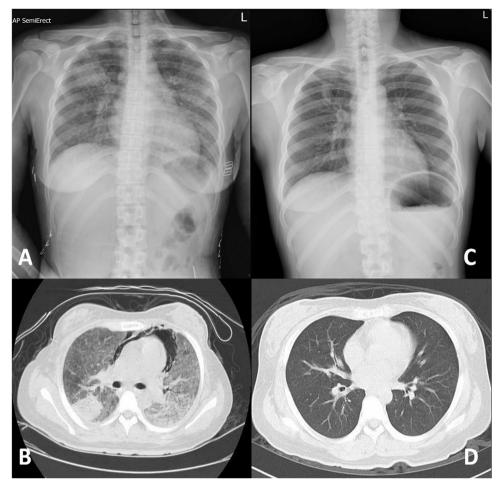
Radiological findings in a 31-year-old woman with HIV infection and community-acquired pneumonia. A chest radiograph at admission revealed bilateral reticulointerstitial infiltrations with focal consolidation over the right upper lung (A), and computed tomography showed ground glass opacities over the bilateral lungs, consolidation over the right lobe, and pneumomediastinum (B). Resolution of the pneumomediastinum and infiltrations over the bilateral lungs on chest radiograph (C) and computed tomography (D) 7 months later.
